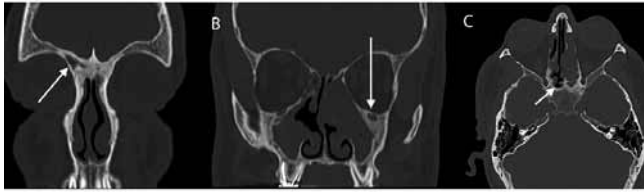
A: Coronal CT scan hypoplastic frontal sinuses. There is a complete absence of the left frontal sinus and the right frontal sinus is hypoplastic with the lateral margin medial to a vertical line drawn through the middle of the orbit (arrow). B: Coronal CT scan with hypoplastic maxillary sinuses. The maxillary sinuses meet four of the five necessary criteria, including an oval-shaped sinus, no pneumatization below the level of the nasal floor, the medial wall of the sinus lateral to a vertical line drawn tangentially to the medial orbital border, and the lateral extension of the medial to a vertical line drawn through the middle of the orbit at the level of the infundibulum (arrow). C: Axial CT scan with hypoplastic sphenoid sinuses with pneumatization limited anterior to the vertical plane of the tuberculum sellae (arrow). Note also the extensive temporal bone pneumatization despite poorly developed sphenoid sinuses.
